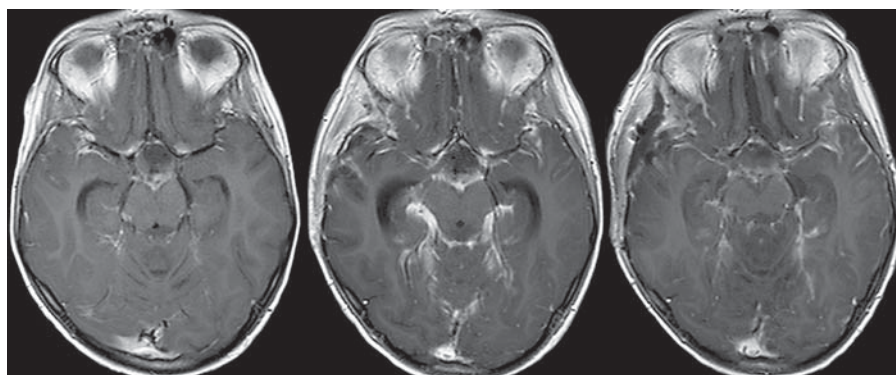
Axial T₁-weighted brain MRI after gadolinium enhancement. Progressive leptomeningeal thickening and enhancement over a 6-month interval (left to right) before initiation of chemotherapy.
